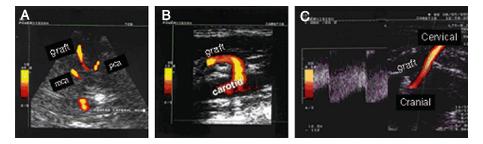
These images demonstrate the application of transcranial colour doppler (TCCD) for graft surveillance. (A, B) Demonstrate that the proximal (B) and distal (A) anastamoses are patent, whilst (C) shows that flow is in an antegrade manner; i.e from the carotid to the middle cerebral as measured at the midpoint of the graft
